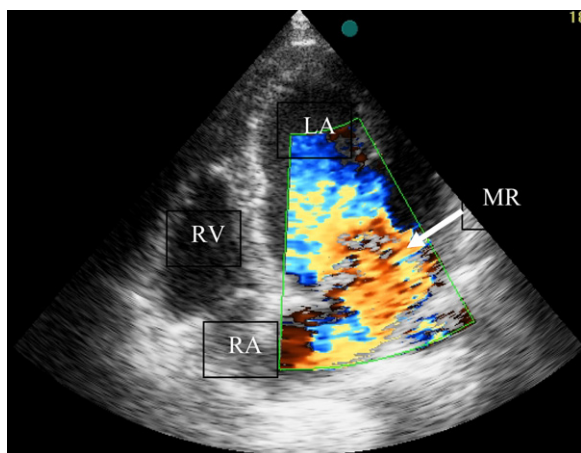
Transthoracic echocardiography in apical 4 chambers shows color flow mapping of severe mitral regurgitation with multiple jets. LA, left atrium; RV, right ventricle; RA, right atrium; MR, mitral regurgitation.
